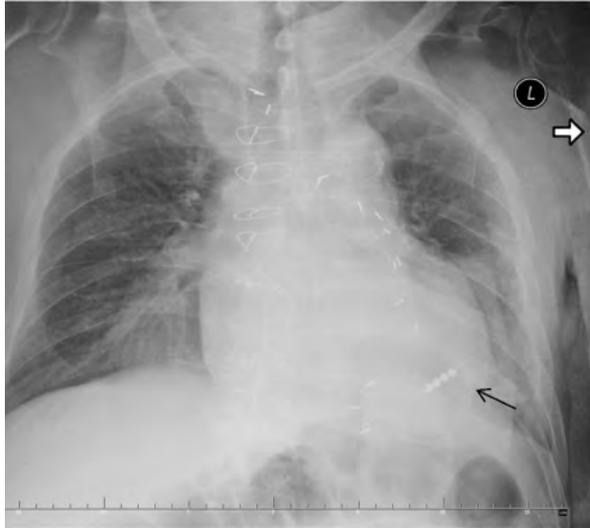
Anterior–posterior chest X-ray. Arrows pointing at the right side of hernia and at the left side the tube curled within the hernia (black arrows)
